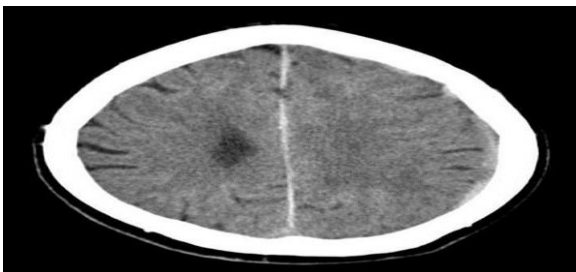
An axial CT of the brain shows interhemispheric hemorrhage of the falx cerebri on a brain window.
